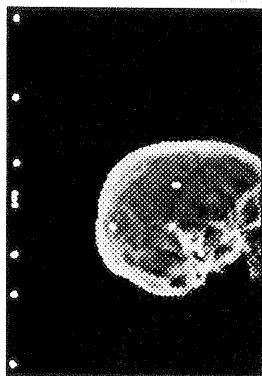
An oblique surviws of the skull scanned at 30 degrees on the CT gantry.
